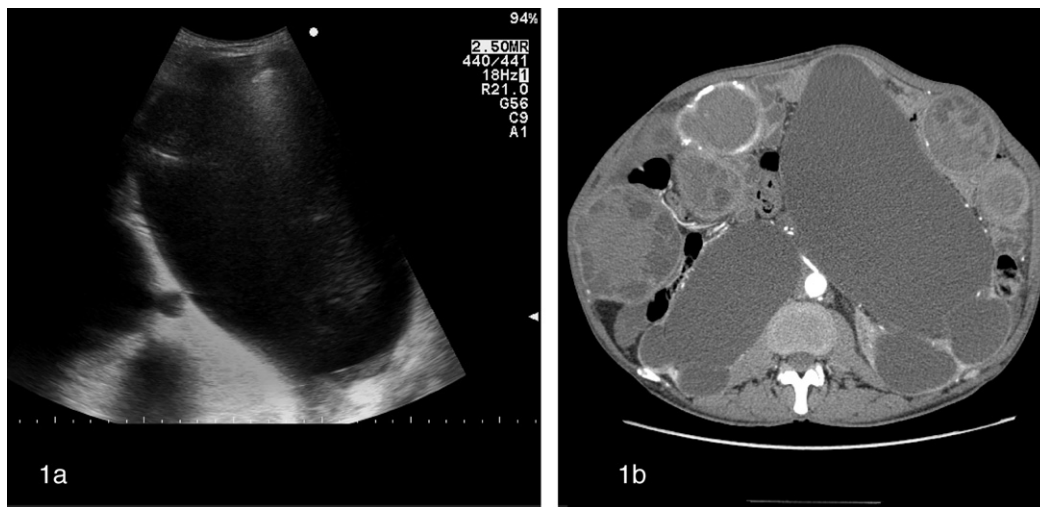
(a) US scan showing a giant fluid collection initially thought to be a CE1 cyst, but corresponding to extreme hydronephrosis due to severe compression on the ureters. (b) CT showing multiple peritoneal echinococcal cysts; the markedly dilated renal pelvis is visible bilaterally.
